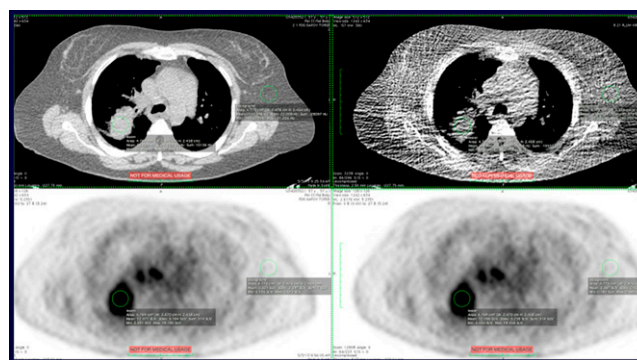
Attenuation correction with extreme CT dose reduction in whole-body FDG PET/CT. Top: CT with regular/clinical dose (left) and extreme dose reduction (right). Bottom: PET with clinically indicated CT dose (left) and CT extreme dose reduction (right). Low-dose CT acquisitions were acquired at 1/10 to 1/60th the dose of a clinical CT exam.
